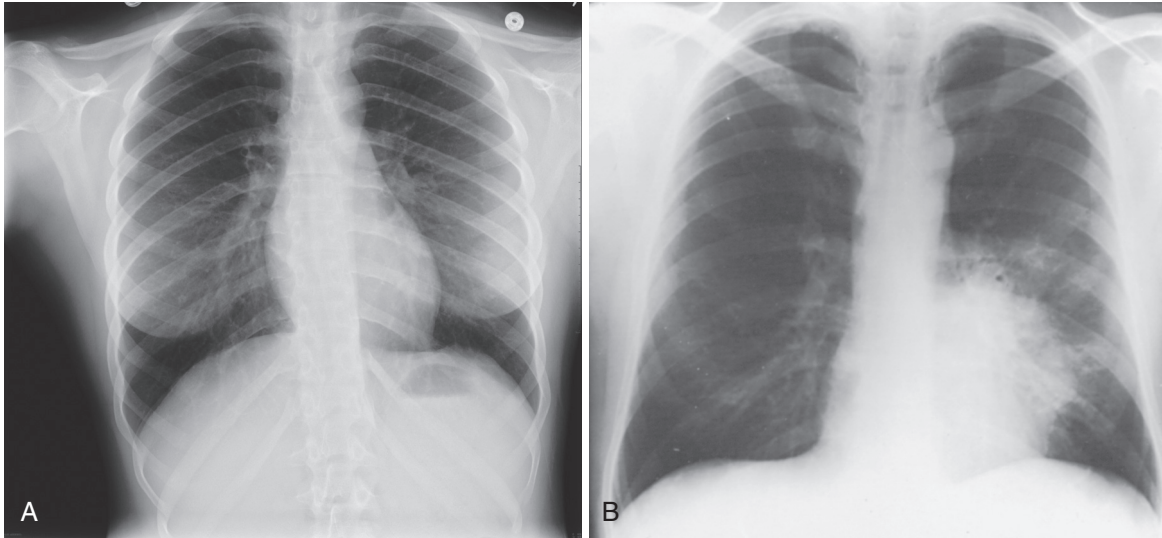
A, Normal chest radiograph. B, Patchy infiltrate representing bronchopneumonia in a patient with *Streptococcus pneumoniae* infection.
